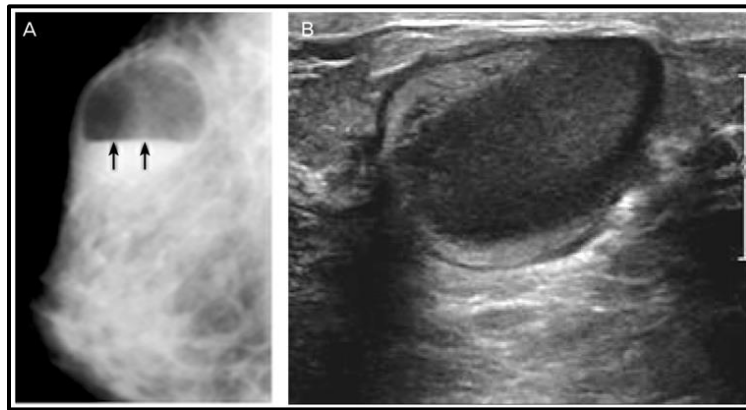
Breast galactocele mammogram (A) and ultrasound (A) (Carol 2005).
